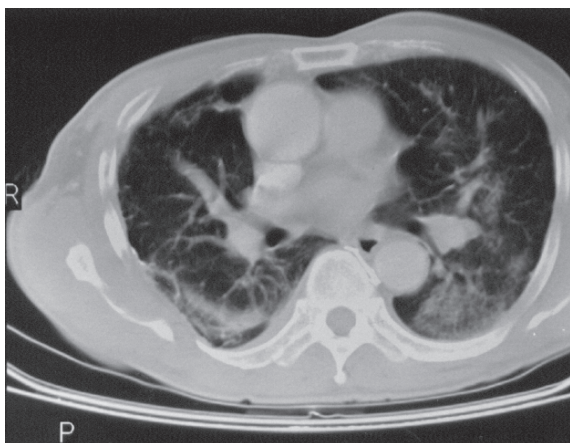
CT Thorax showing areas of patchy ground-glass opacity within the left lung. Scarring and volume reduction of the right lung is related to the previous surgery.
